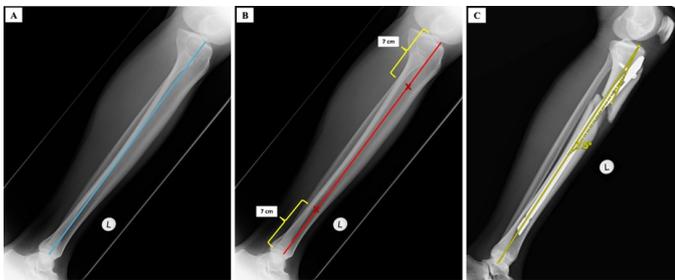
Lateral view plain radiographs of the tibia. (A) Represents the mechanical axis (blue longitudinal line), (B) shows the anatomical axis (red longitudinal line), determined by a line passing through the medullary canal, positioned 7 cm from the plateau and 7 cm from the plafond, and (C) depicts a 7.5-degree procurvatum malalignment of a proximal third tibial fracture post-intramedullary nail (IMN), as indicated by the yellow line.
